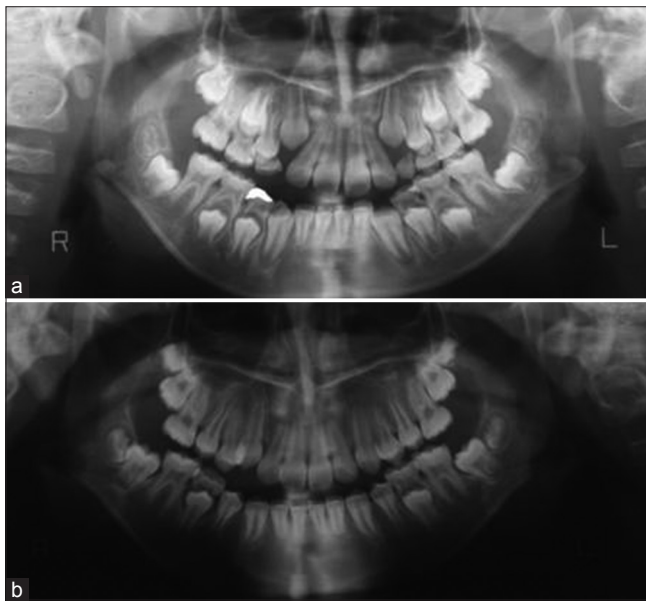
Panoramic radiographs of patient 2: (a) Mixed dentition, (b) pretreatment
